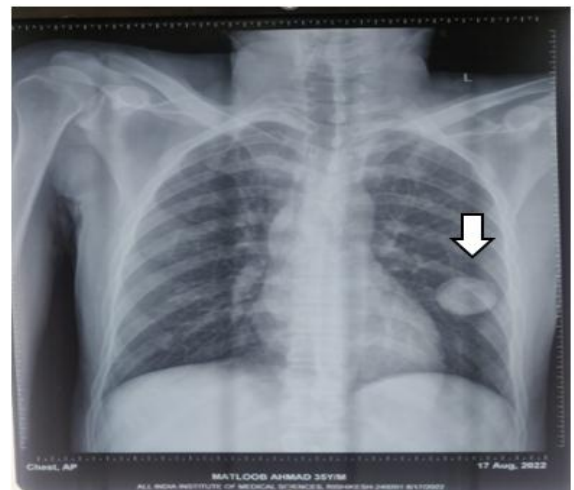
Chest X-ray PA view erect showing rounded opacity in left lung field depicted by arrow.
